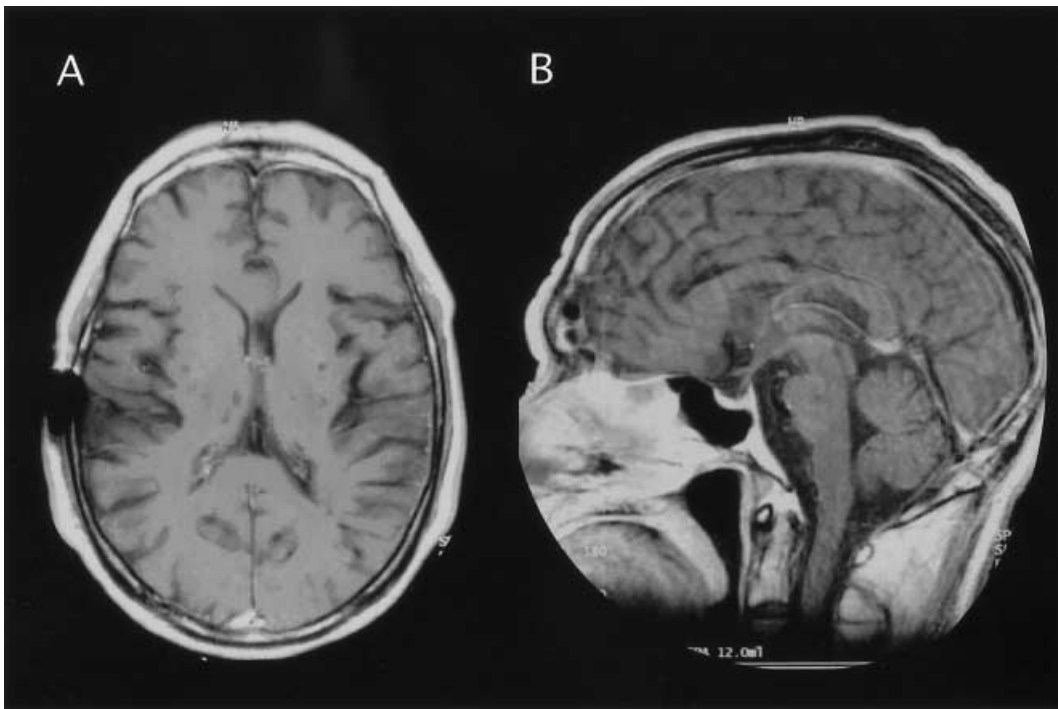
T1-weighted images with gadolinium-diethylenetriaminepenta-acetic acid administration at 16 months after the operation, the axial view (A) and the sagittal view (B). No recurrent tumour mass can be seen
